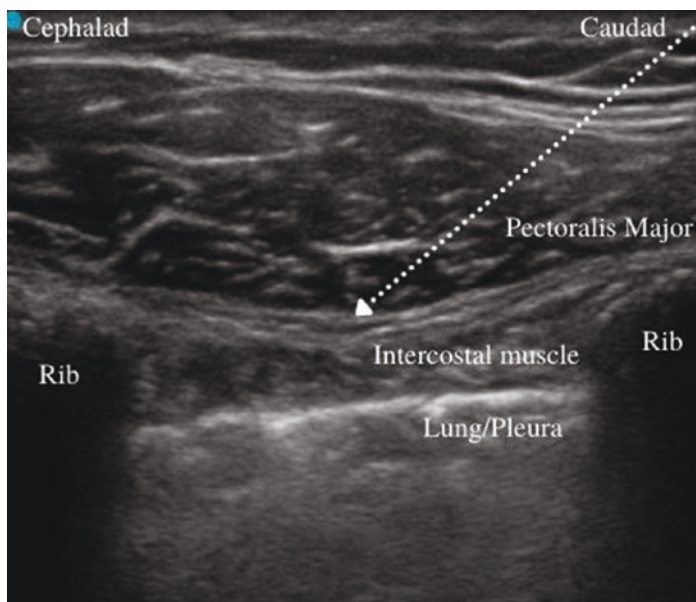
Ultrasound image of parasternal plane block. Dotted line demonstrates needle trajectory with arrow pointing to site of local deposition
